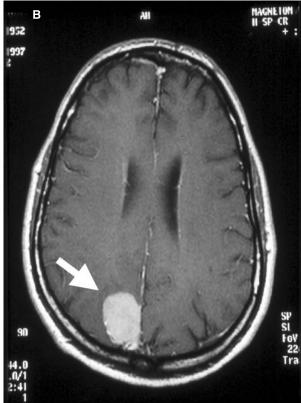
(A–C) Axial T1-weighted images of the brain showing a right meningioma of the falx (A), a right meningioma of the occipital lobe (B) and a right vestibular schwannoma (C) (white arrows) in a patient with mosaic NF2 [reprinted with permission from Ruggieri and Huson 2001].
